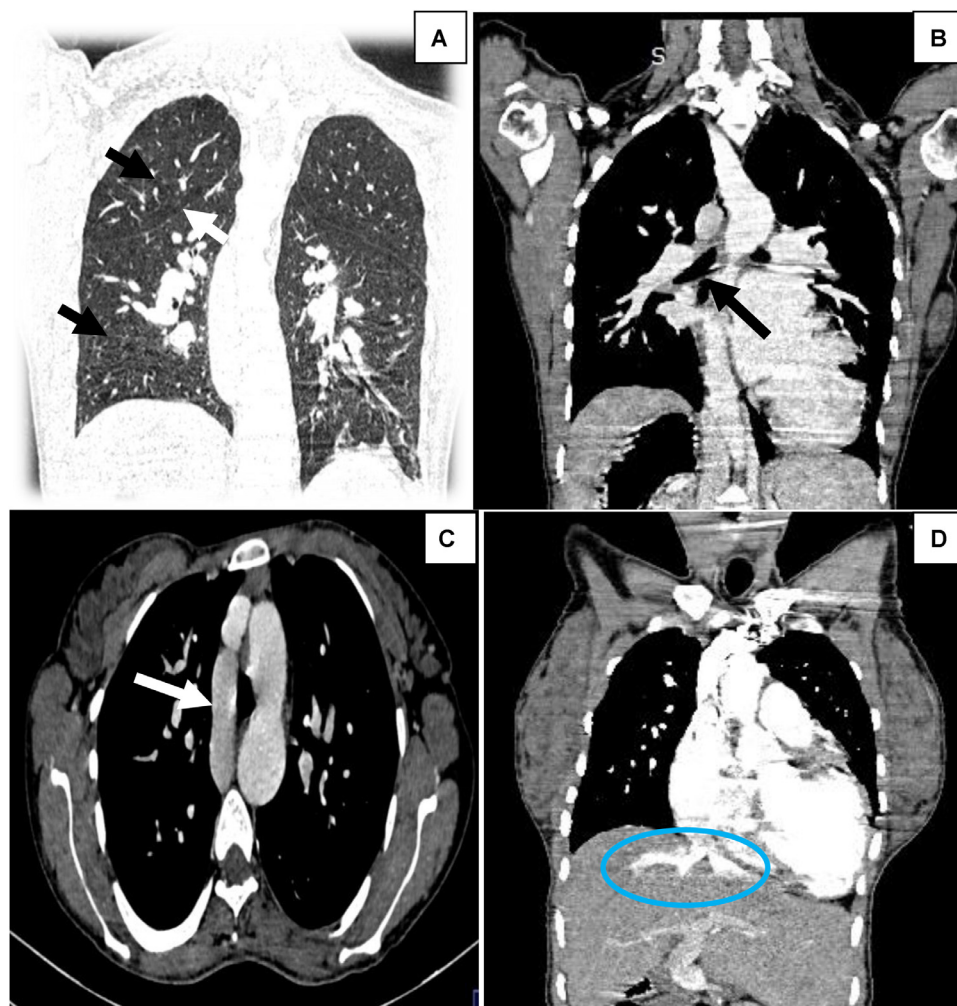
The injected thoracic CT scan showed a bilobed right lung (black arrow “A”), a right fissure symmetrical to the large left fissure (white arrow “A”), and hypoplastic bronchial roots (B). Additionally, there was dilation of the azygos vein draining into the superior vena cava (SVC) (C), as well as dilation of the hepatic veins draining into the right atrium (RA) (D).
